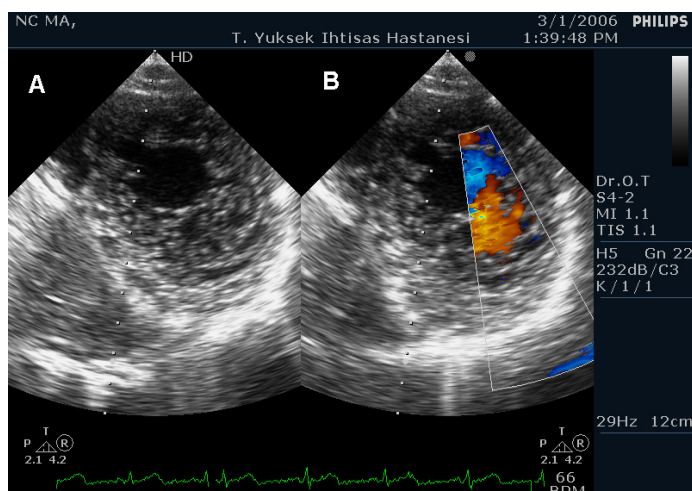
Modified apical view of the left ventricular apex in a patient with isolated left ventricular noncompaction. Two-dimensional echocardiography reveals the 2 layers of myocardium (compacted and noncompacted), excessive numbers of large trabeculae (Panel A), and multiple deep intertrabecular recesses filled with blood from the ventricular cavity as shown on color Doppler (Panel B).
